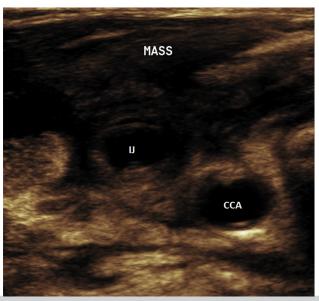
Duplex ultrasound scan of the right neck showing overlying abscess (*MASS*) in relation to the internal jugular (*IJ*) vein and common carotid artery (*CCA*).
